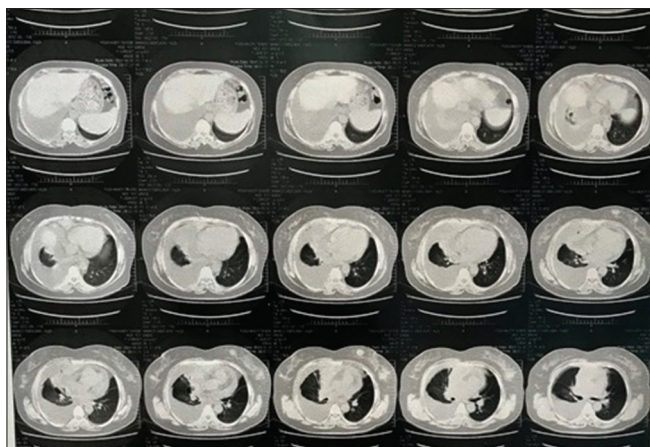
Computed tomography showing severe right pleural effusions with passive collapse of the right lower and middle lobes. Mild pericardial effusion is visible. There are a few hyperdense soft tissues in the both breasts
